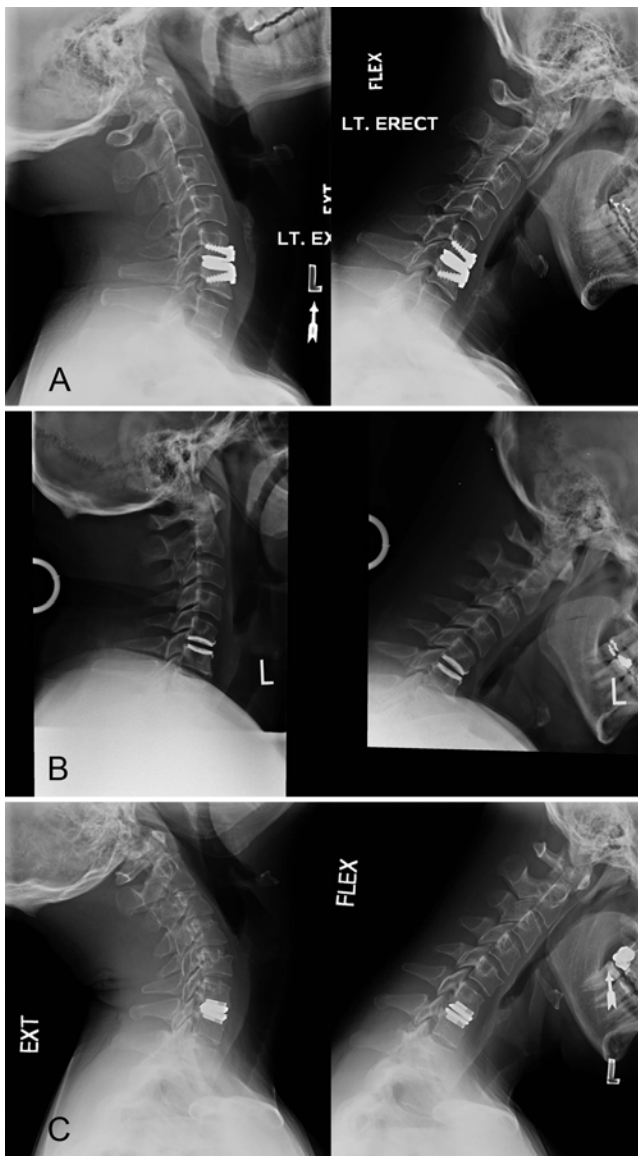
Examples of maintenance of ROM at the index level for each artificial disc: Prestige ST (A), Bryan (B), and ProDisc-C (C). Extension (left) and flexion (right) dynamic lateral radiographs of the cervical spine obtained during follow-up.
